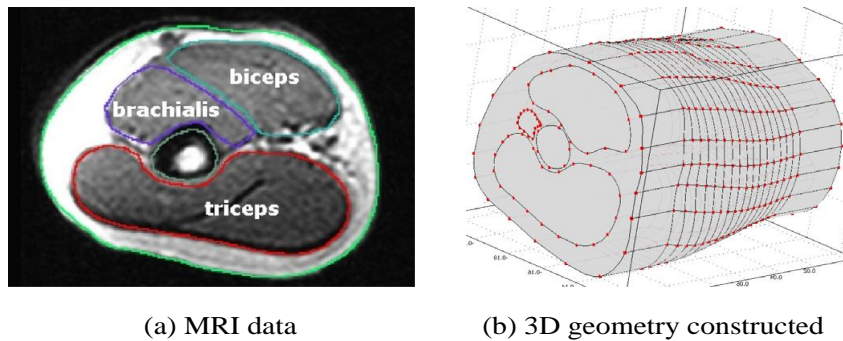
(a). MRI of upper arm. (b) 3D geometry constructed with COMSOL (from [56], Fig 10).
